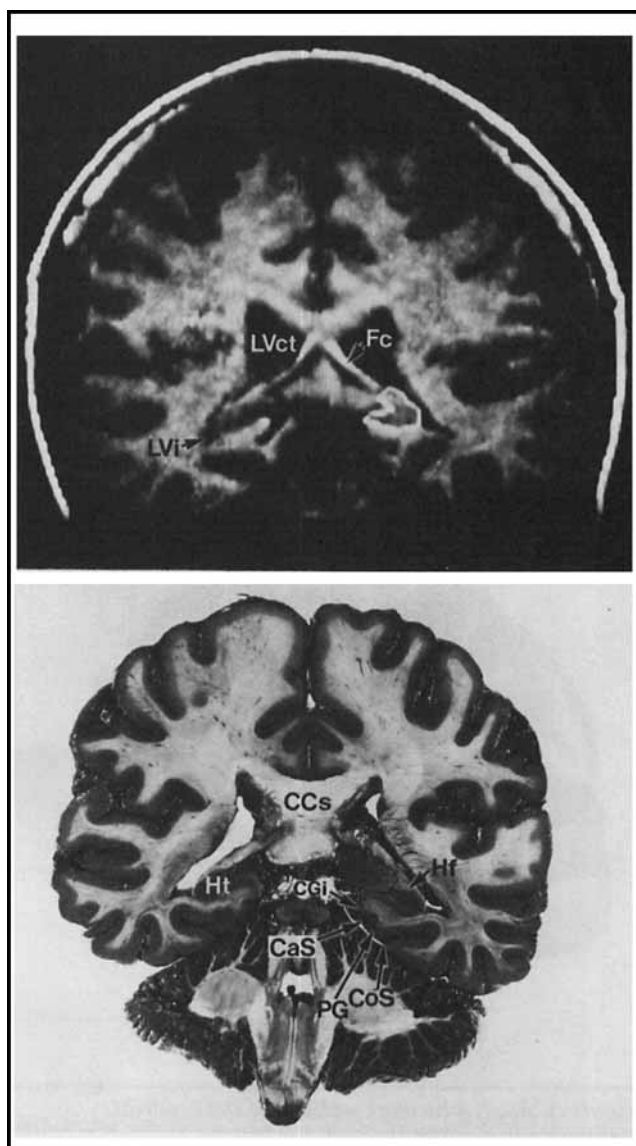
Angled coronal sections of the cerebral hemispheres passing through the splenium of the corpus callosum and isthmus of the cingulate gyrus. (Upper plate) MRI with hippocampal tail outlined on the left. (Lower plate) Brain section showing the transition from fimbria of hippocampus to crus of fornix. (Reproduced with permission from Basic Human Neuroanatomy: An Introductory Atlas, 4th ed, p 167, copyright 1991, Little, Brown and Company.⁶⁵) For abbreviations, see figure 1 legend.
